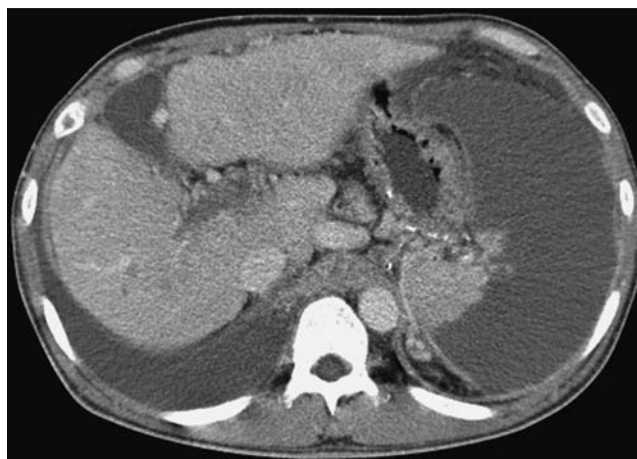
Follow-up computed tomography scan showing remnants of cyanoacrylate within the splenic vein and persistent, large hypoattenuated lesions in the spleen.
